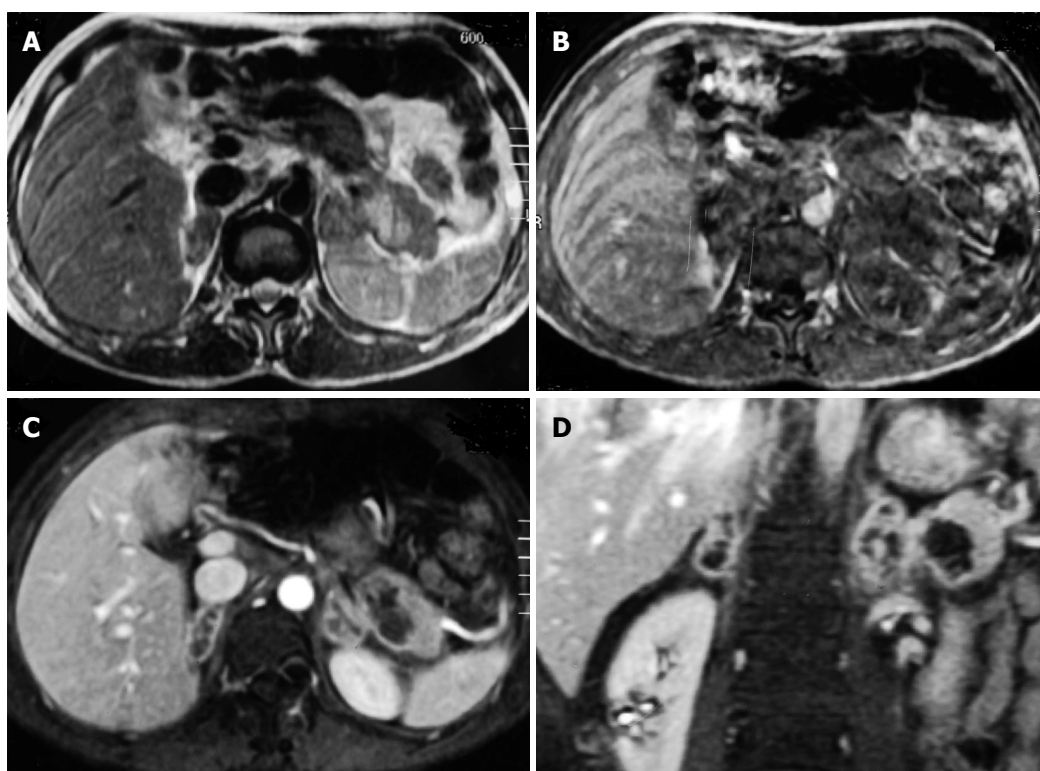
A 44-year-old man who has hypoglycemia and low blood pressure with primary adrenal insufficiency due to adrenal tuberculosis. MRI scans reveal the mass-like enlargement of bilateral adrenal glands on axial T1- weighted image (A) and T2-weighted image (B), but its contours are preserved with peripheral enhancement on contrast-enhanced axial (C) and coronal (D) T1-weighted image. MRI: Magnetic resonance imaging.
